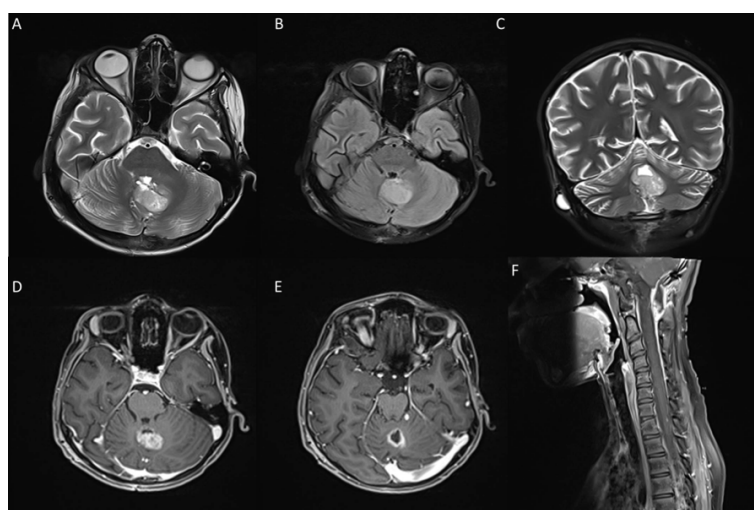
One-month postoperative follow-up MRI.
